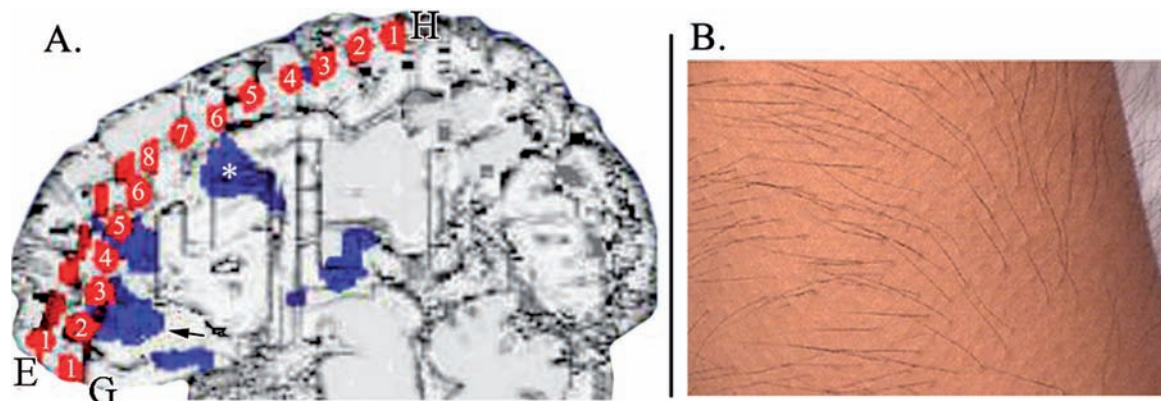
Right cingulate focus documented by subtraction of interictal from ictal single-photon emission computed tomography with MR-CT co-registration and 3D-rendered magnetic resonance imaging. A. Image demonstrates that the hyperperfusion (coded blue) is in the medial part of the rectus gyrus, hypothalamus, and thalamus. One of the actively hyperperfused areas is in sACC (arrow) is close to electrodes G2 and G3. A second site of hyperperfusion is dorsal in pACC and a third is in midcingulate cortex (asterisk). B. Photograph of skin during a pilomotor seizure. Used with the generous permission of D.W. Seo (Seo *et al.*, 2003).
